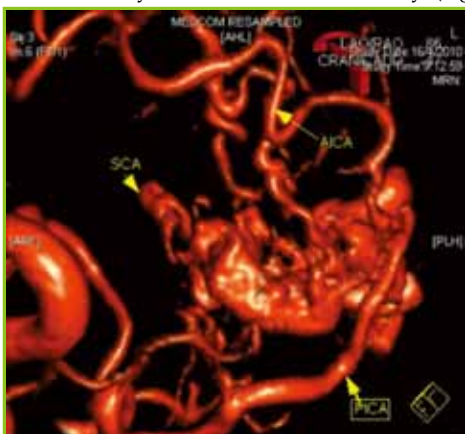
3D CT angiogram of a girl of 8 following an incidental finding of an AVM on brain CT after a minor head injury.
